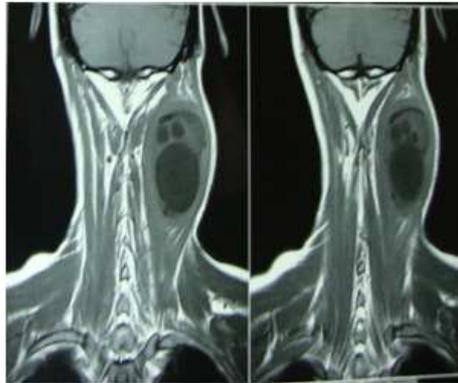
MRI Appearance of the Cyst
